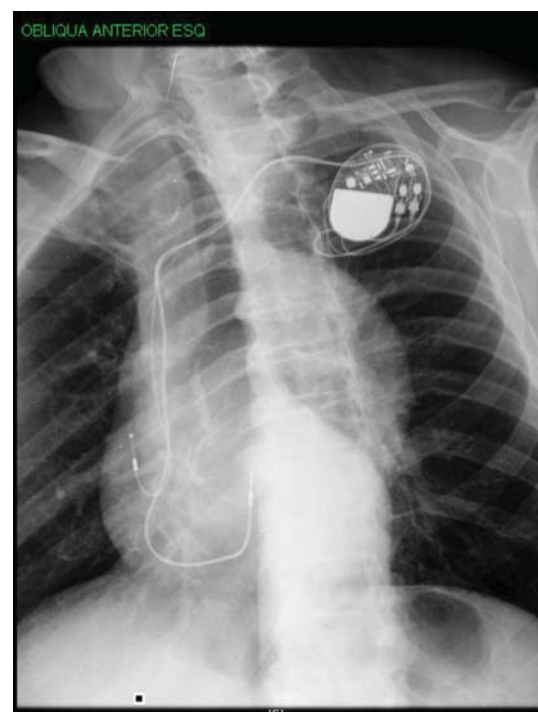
Left anterior oblique chest radiograph showing the position of the ventricular lead within the RVOT.
